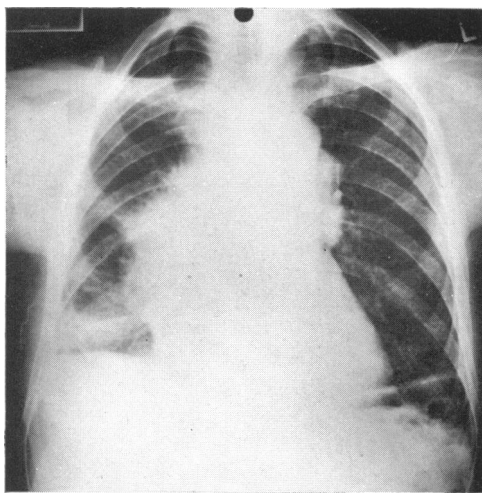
Chest X-ray from a man (Case 2) treated by multiple surgical operations, including distal pancreatectomy and total gastrectomy. Death finally resulted from this massive metastatic carcinoma in the chest.
